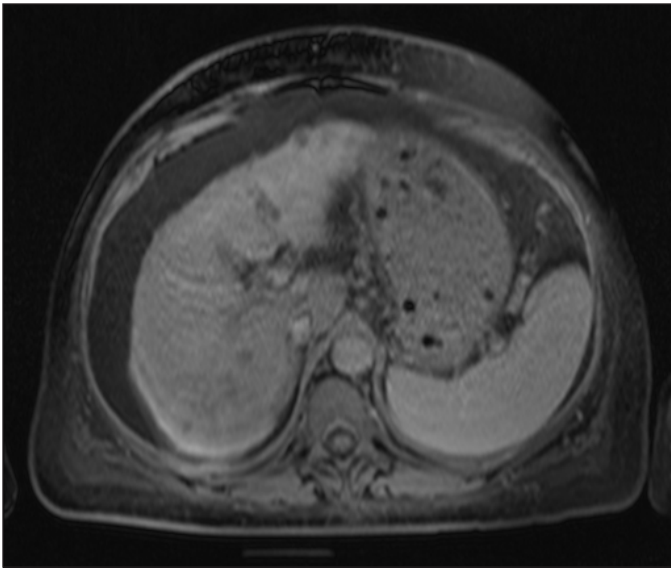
Cross-sectional abdominal MRI showing concomitant cirrhotic liver with multiple ill-defined heterogeneous lesions.
